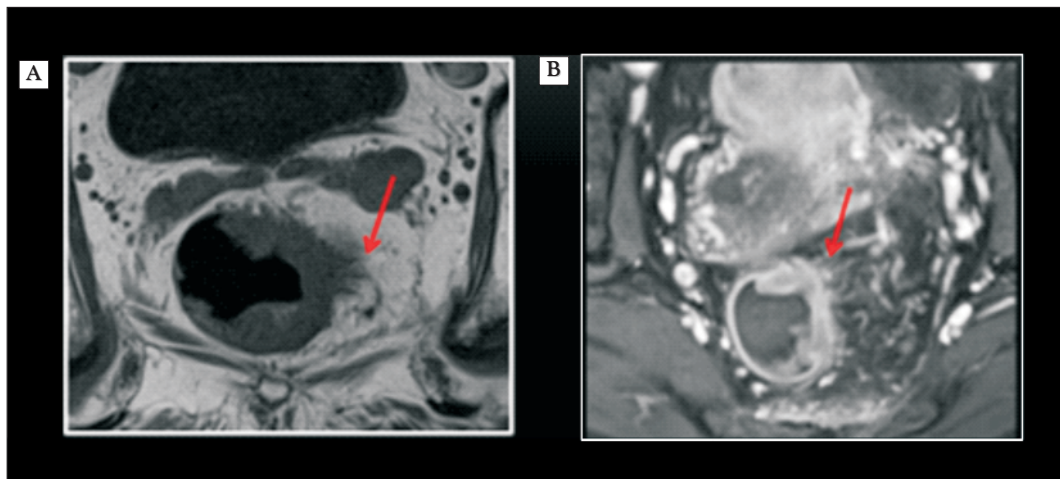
MRI (A) native axial and (B) axial T1-weighted FS with radiocontrast agents presenting a rectal tumour with fine spiculations (arrow) towards the mesorectum. None of the images shows very clear the nature of these spiculations (T3 tumoral extension vs. T2 with desmoplastic reaction)
